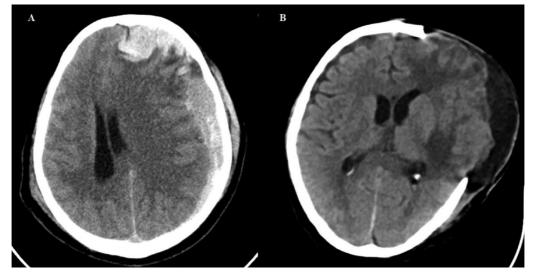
External cerebral herniation. Noncontrast CT head showing (A) left FTP SDH of 12 mm thickness with a midline shift of 1.6 cm and left frontotemporal hemorrhagic contusion. (B) Postcraniectomy with external cerebral herniation with 1.61 cm of herniated brain tissue through the craniectomy site.
